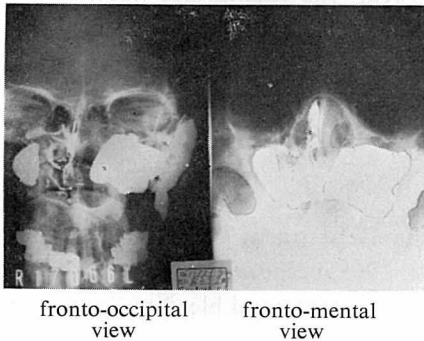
X-Ray examination of the maxillary sinus by instillation of contrast medium.
